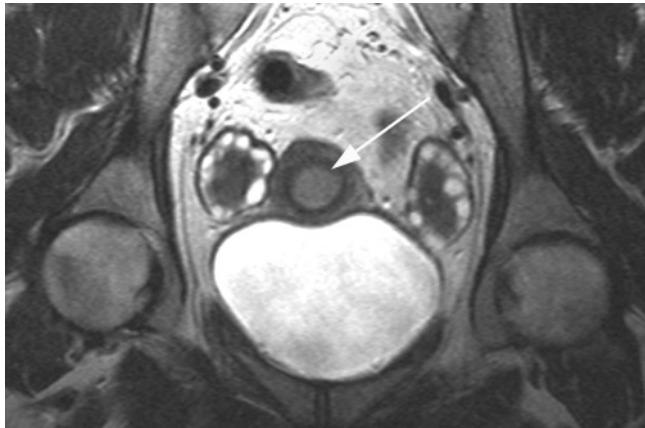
Endometrial carcinoma in a patient with polycystic ovary syndrome. Oblique (short-axis view of the uterus) T2-weighted ETSE image shows low-signal-intensity central ovarian stroma and capsule with numerous small peripheral follicles. The endometrium is thickened (arrow). Biopsy revealed endometrial carcinoma.
